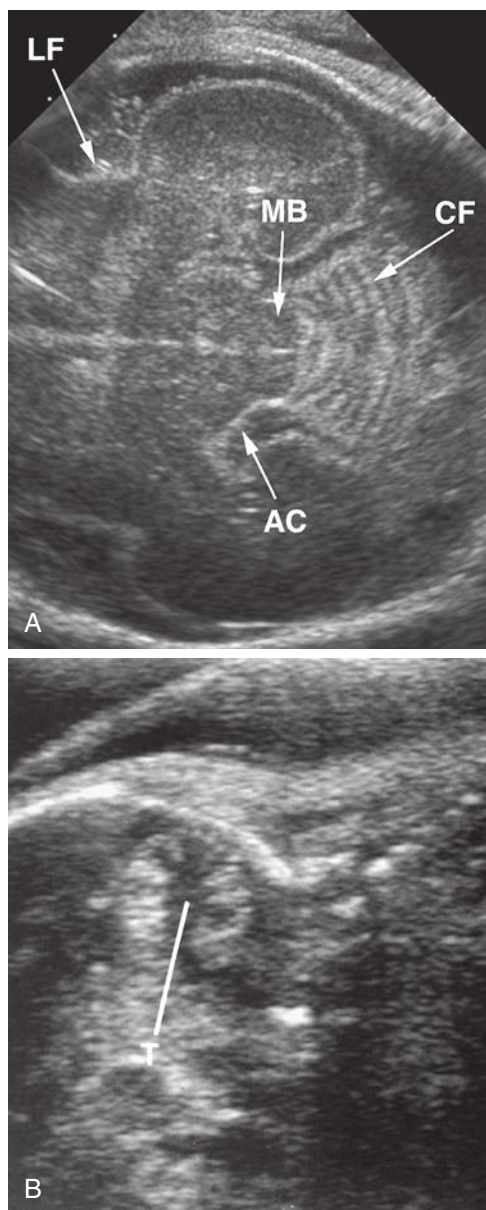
A, Posterior fossa view (transverse axial) demonstrating cerebellar folia (CF). AC, ambient cistern; LF, lateral fissure; MB, midbrain. B, Parasagittal sonogram of the posterior fossa. Cerebellar white matter tracts (T) are well seen. The bright margin of the cerebellum is “artifactual” in that it is due to reflections from leptomeninges drawn into the cerebellum by folia formation (gray matter is hypoechoic).
